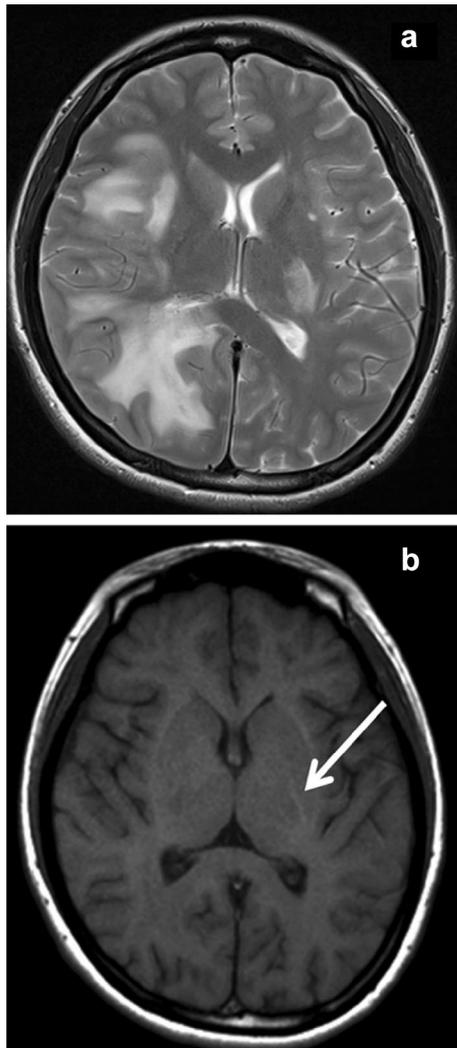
Twenty-two-year-old female with ADEM (Case 3). a T2-weighted image (T2WI) on admission (20 days after onset) demonstrated hyperintense lesions in right hemisphere and left internal capsule or thalamus. b T1-hyperintensity foci appeared in internal capsule on 43 days after onset. This lesion showed linear shape (arrow)
